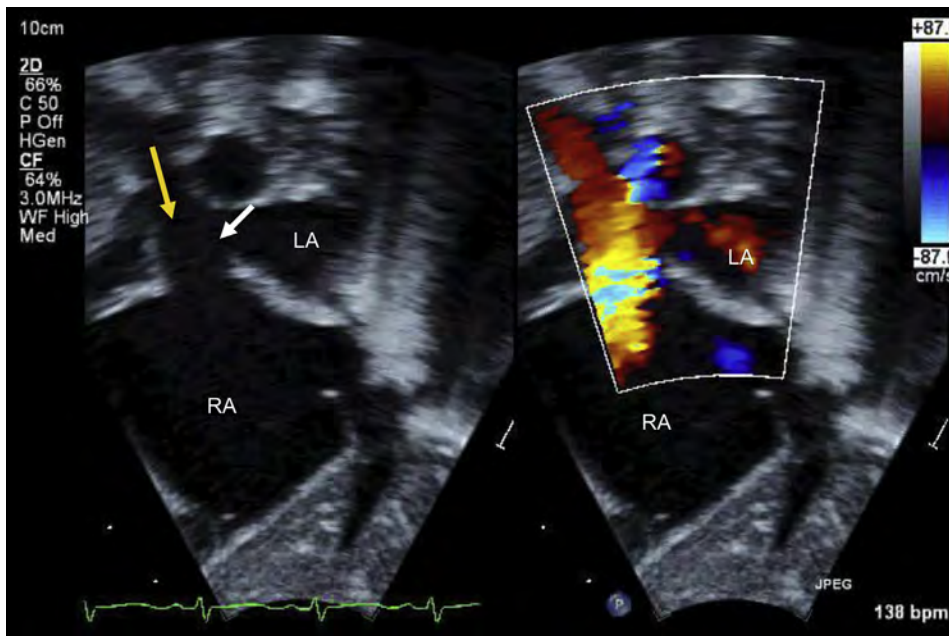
Transthoracic echocardiogram of a SVC type venosus ASD in subxiphoid sagittal view without and with color in a pediatric patient. The *yellow arrow* represents the right superior pulmonary vein and the *white arrow*, the defect entering the atrium. See also [Video 9](#).
